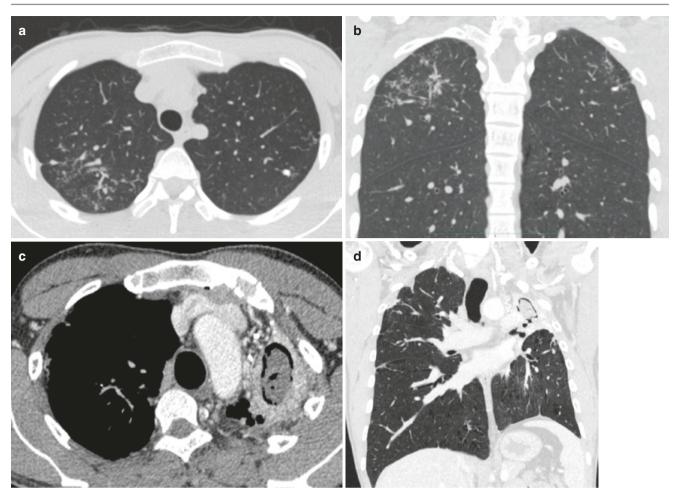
Tree-in-bud opacities in a sputum-positive case of tuberculosis. (a, b) Axial and coronal CT images show tree-in-bud opacities in upper lobes. Fungal ball in another patient presenting with hemoptysis.
